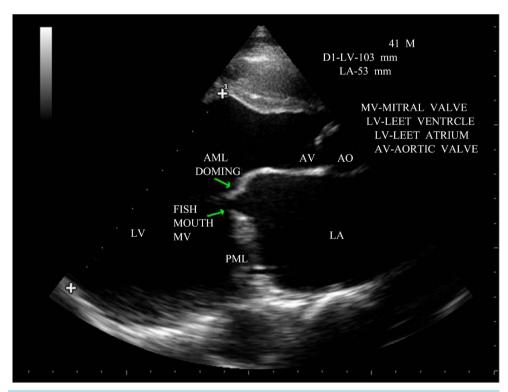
Parasternal long axis view showing the massive LV (left ventricular) dilatation, "doming" motion of anterior mitral leaflet (AML) and" fish-mouth opening" or "buttonhole" deformity of MV (mitral valve).
